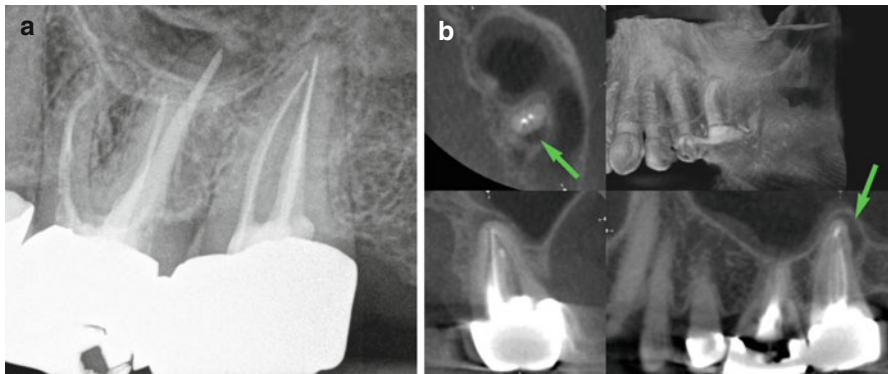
(a) Periapical radiograph of a maxillary second molar tooth. (b) CBCT of the same tooth clearly showing a region of radiolucency at the distal apical aspect of the tooth; (*green arrows*)
